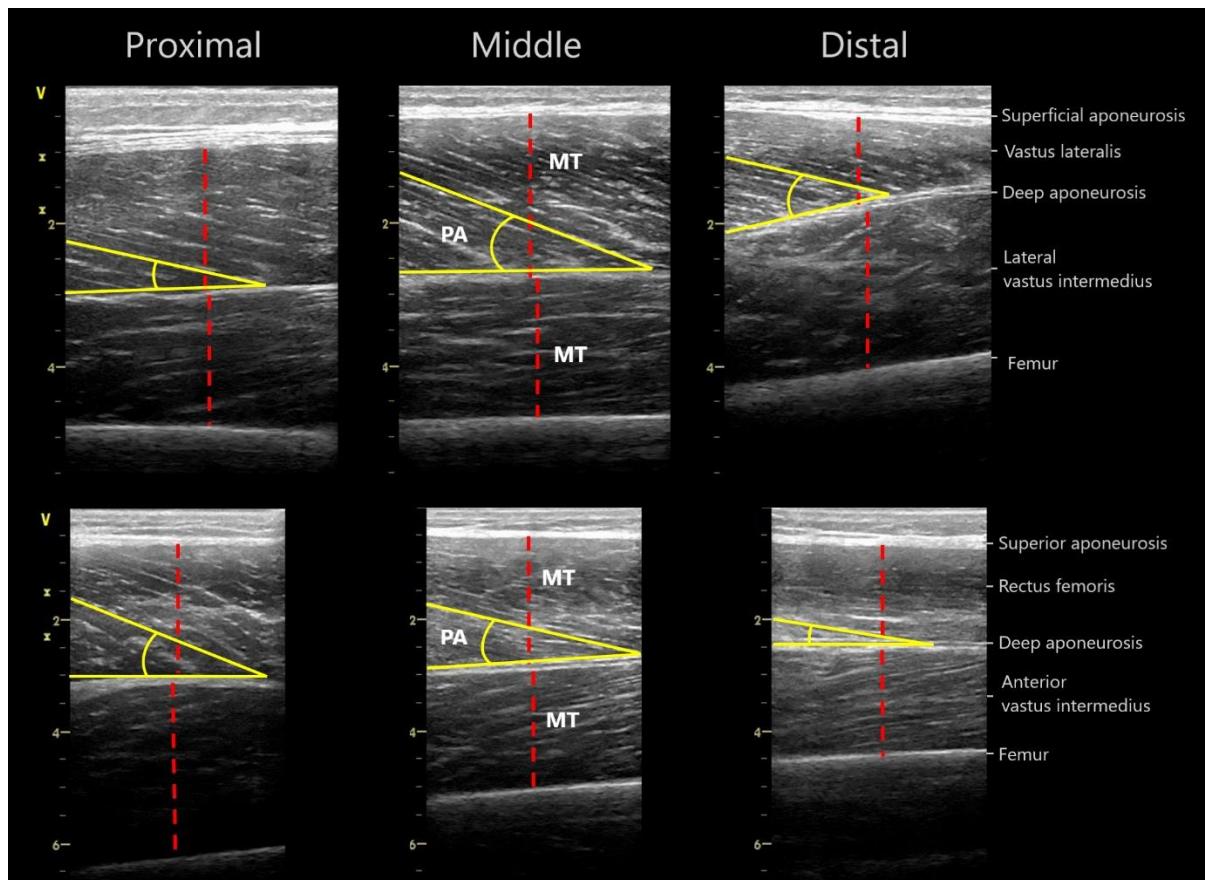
Representative proximal, middle, and distal B-mode ultrasound images of the lateral (top) and anterior (bottom) quadriceps muscles. MT = muscle thickness. PA = pennation angle.
